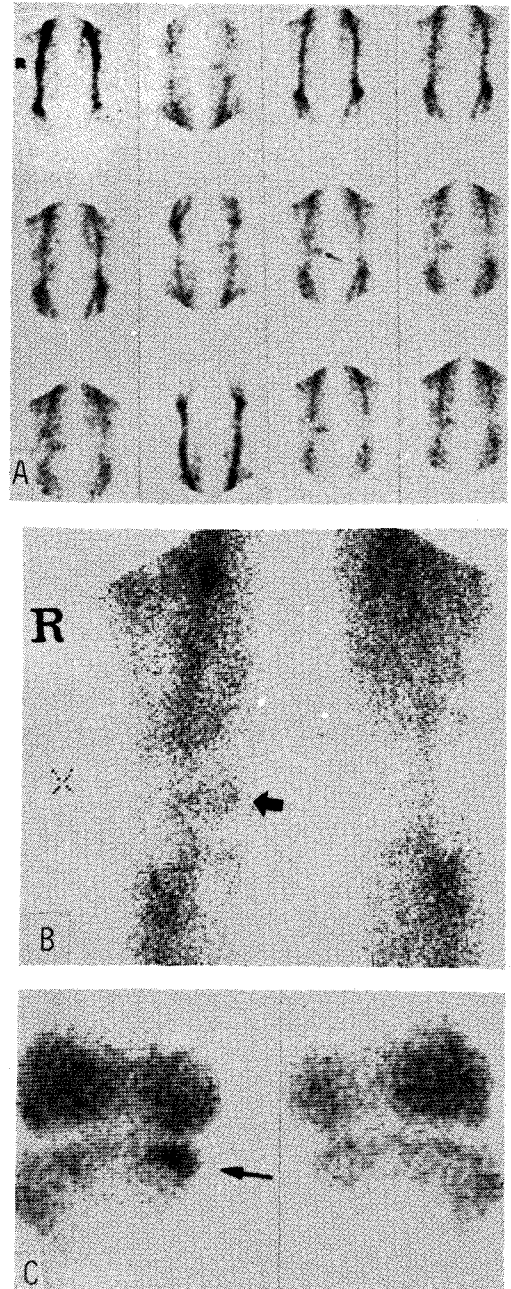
Scintiimages showing blood flow increase in the medial aspect of the right knee joint space on the scintiangiogram (A) and 2 mins blood pool image (B). Static knee joint scintigram (C) showing radionuclide accumulation localized sharply to the medial plateau with diffusely increased activity in the opposing femoral condyle of the right knee.
